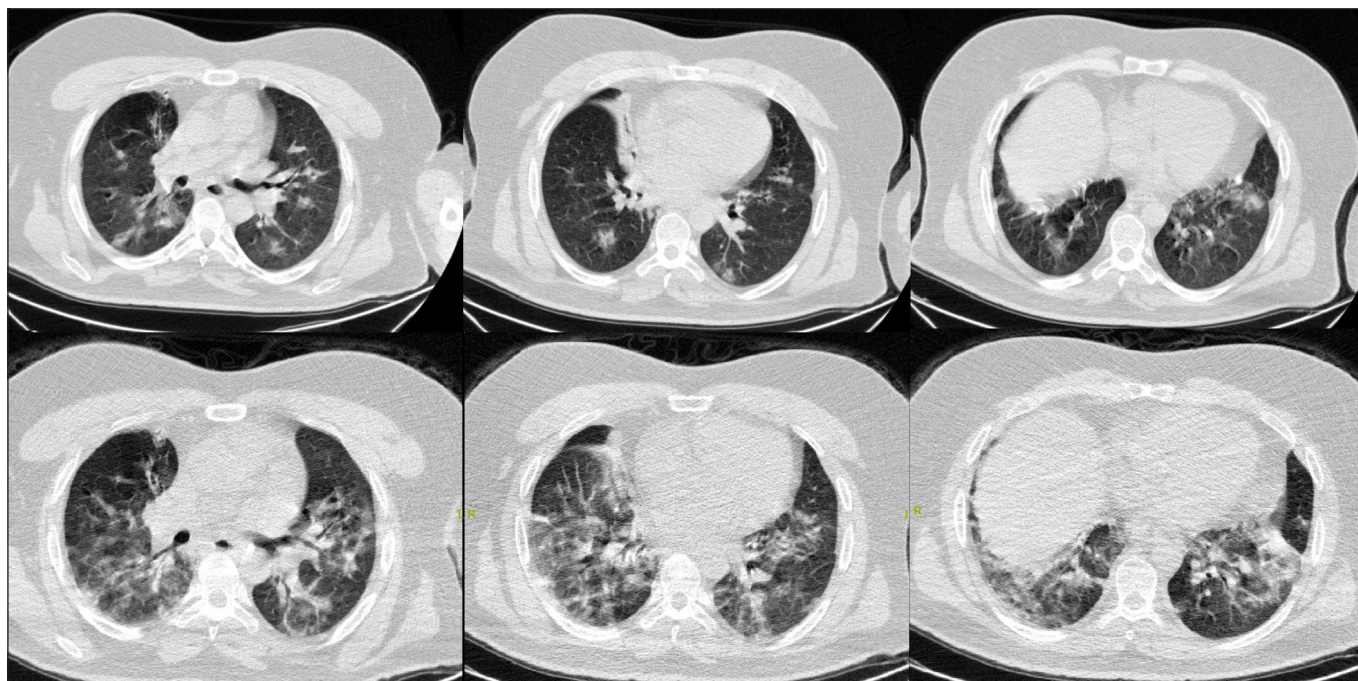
Chest computed tomography findings on initial admission (first row) and on hospitalization (second row).
